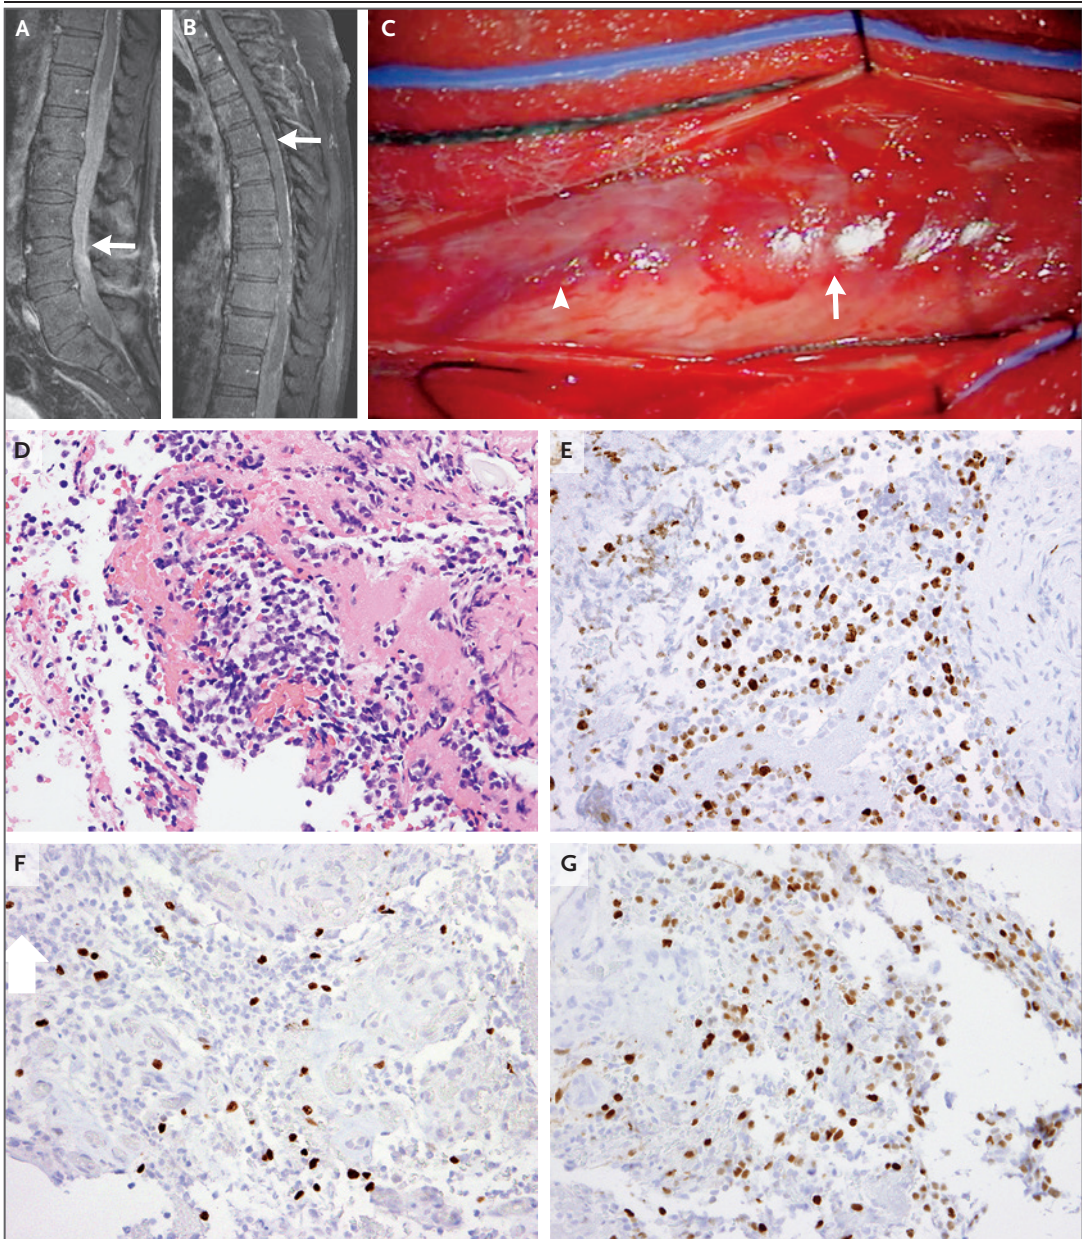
Findings Obtained on MRI, during Surgery, and after Biopsy.
